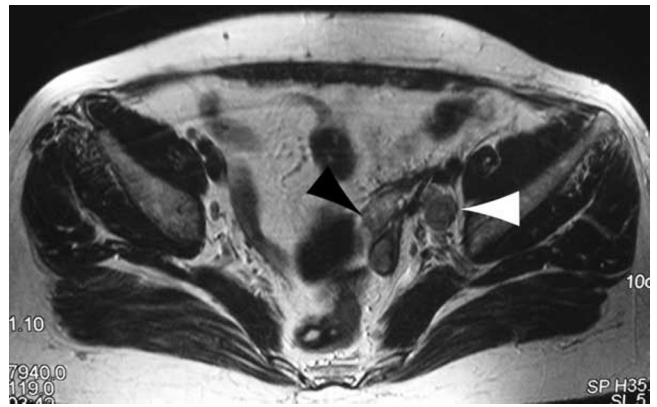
50-year-old woman with ovarian sarcoidosis. T2-weighted axial pelvic MRI depicts regression of the left adnexal mass (black arrowhead) despite persistence of the left internal iliac lymph node (white arrowhead) with the complex cystic lesion.
